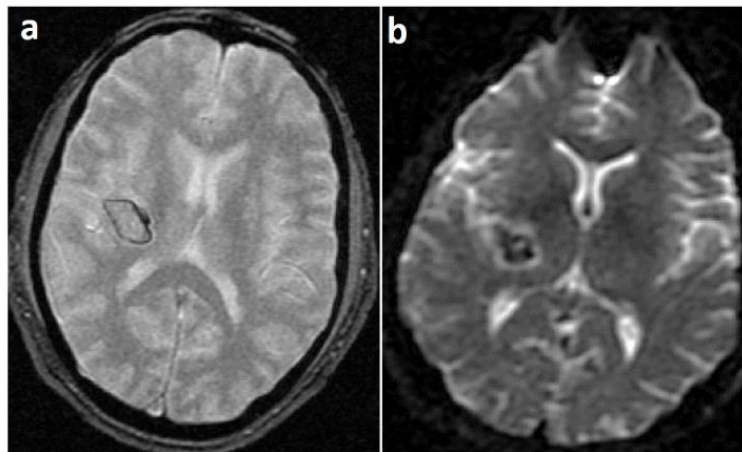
(a&b) (a) T2*WI and (b) DWI-b0 showed hypo intense signal signifying acute Rt. sided cerebral hemorrhage.
